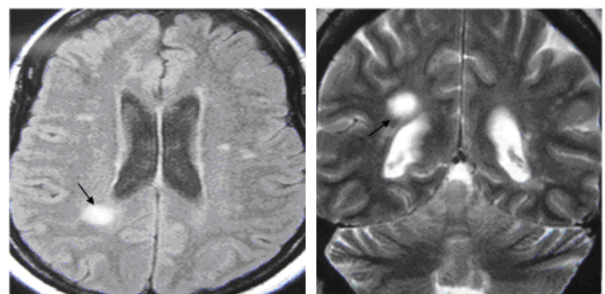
MRI brain 3 months later
